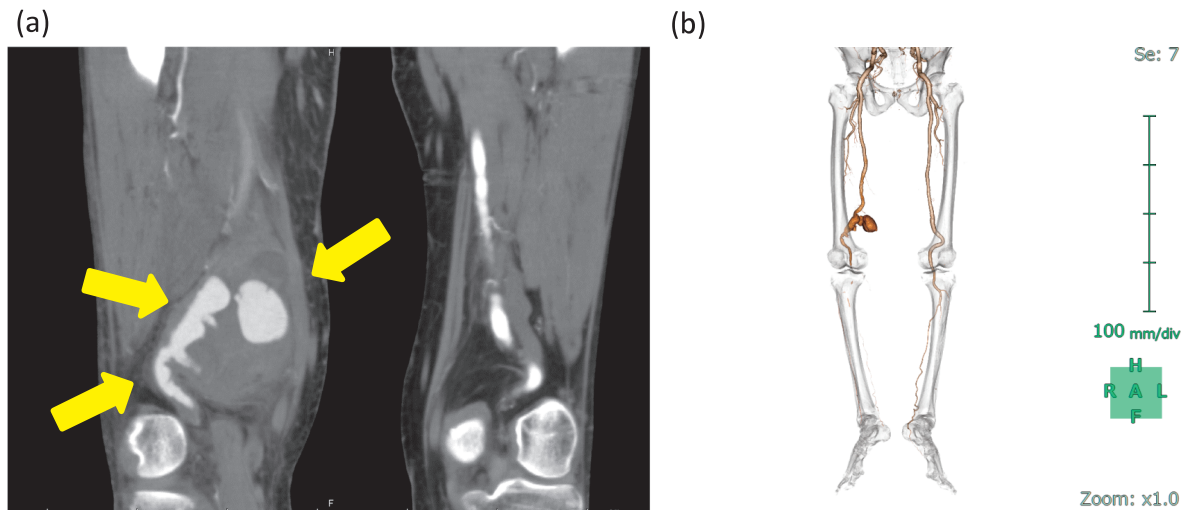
Computed tomography angiogram showing a right distal SFA aneurysm.
